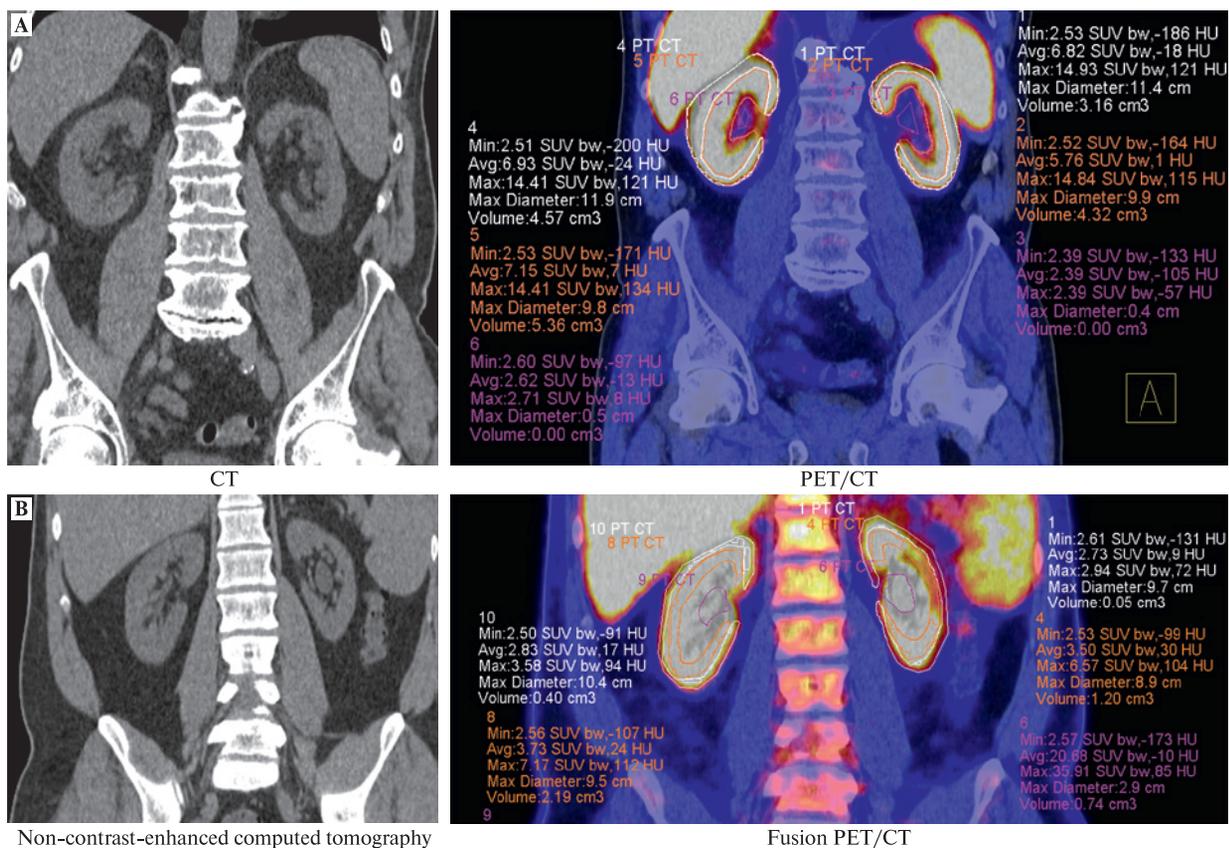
Results of a standard comparative analysis of PET/CT images, selected for retrospective study (on the right, simultaneous visual and mathematical calculation of ¹¹C-choline activity in the kidney parenchyma)
